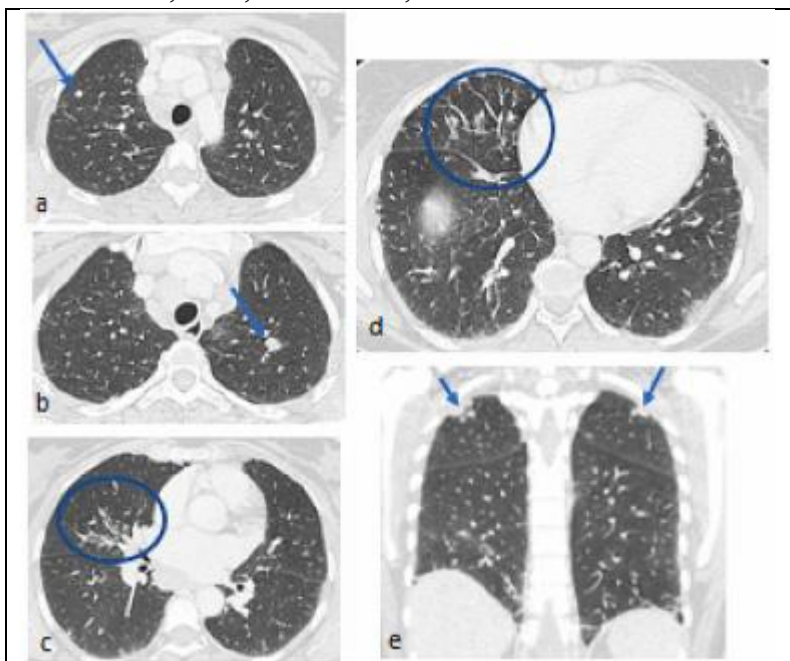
Solid nodules of the left and right upper lobes (Arrows) are seen in the axial CT sections (a, b) and coronal section (e). Peribronchovascular heterogeneous, poorly defined consolidation is seen in the middle lobe of the axial CT section (c, d).
